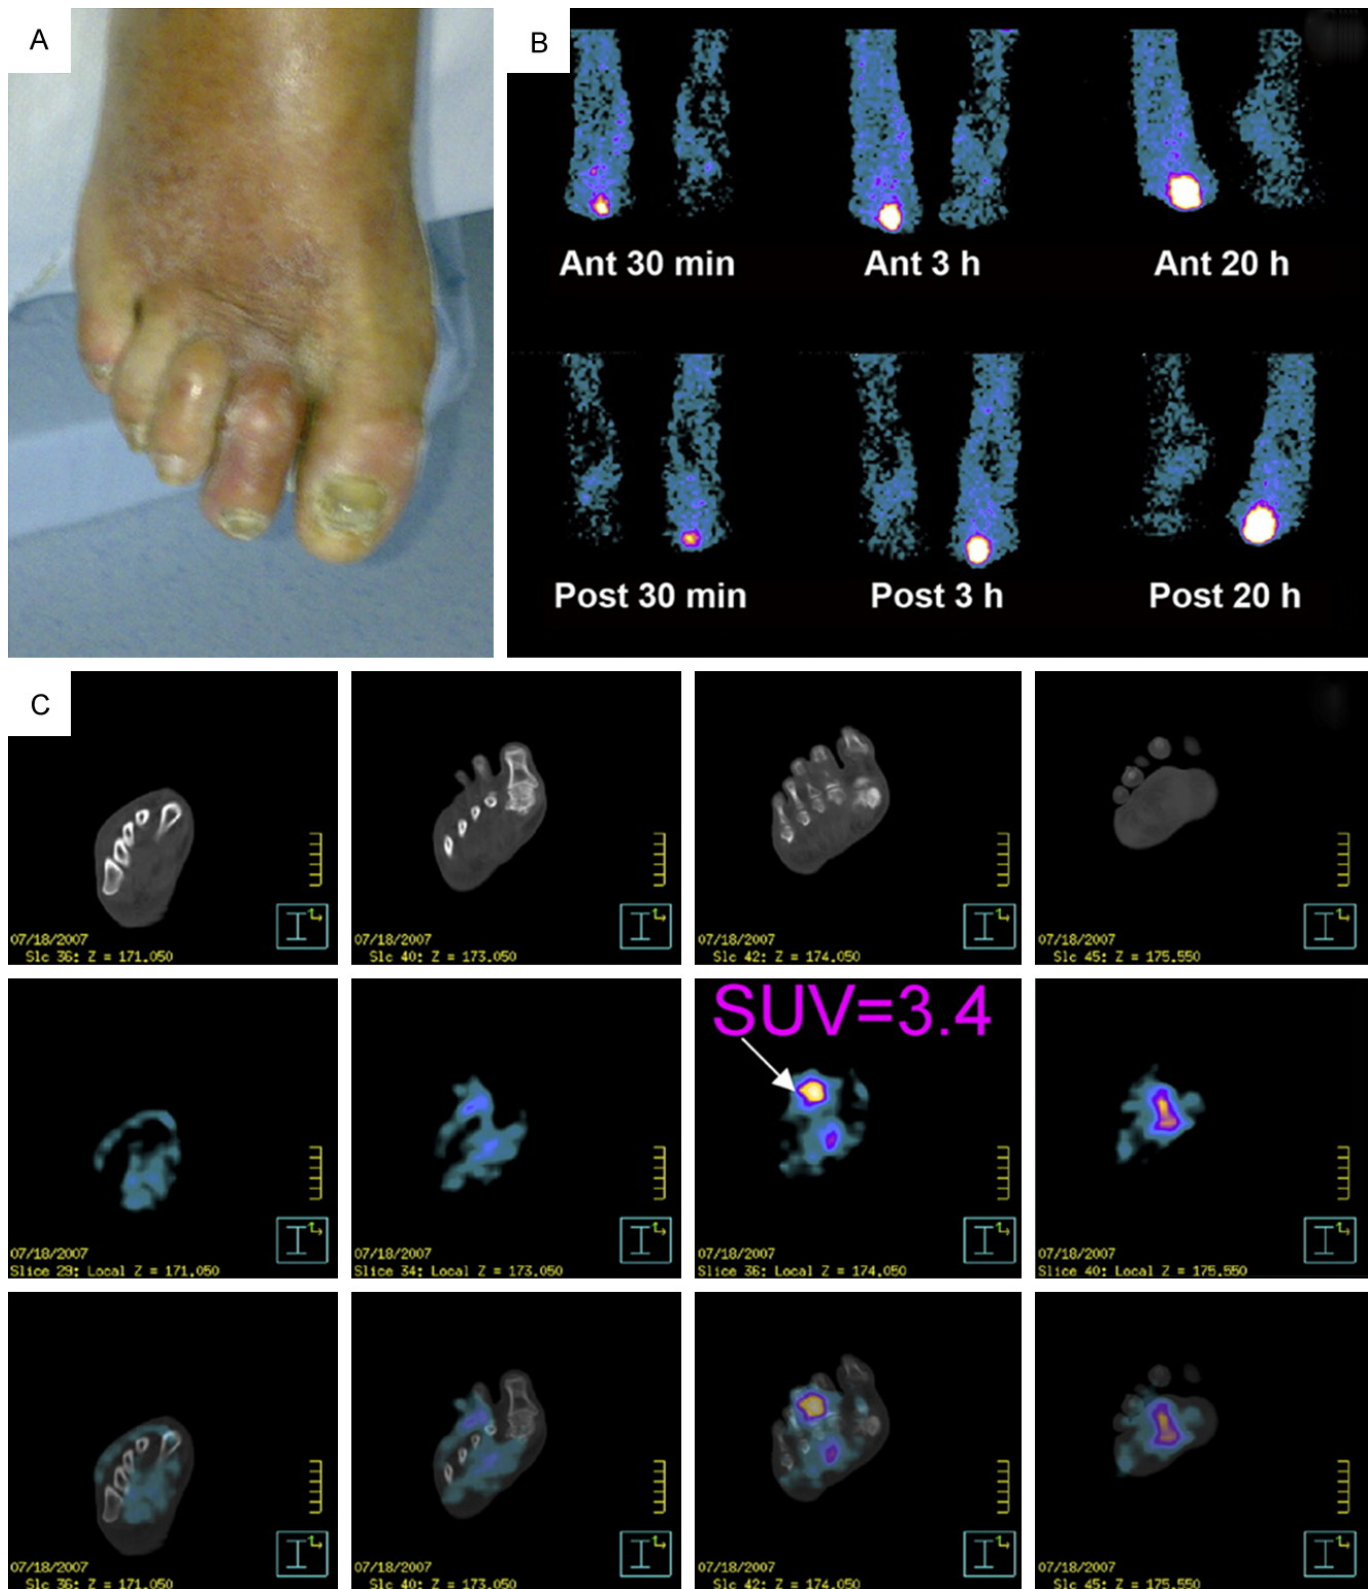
Concordant positive results for osteomyelitis in a diabetic foot patient. (A) Clinical image. (B) Anterior and posterior WBC scintigraphy at 30 min, 3 h, and 20 h showing T/B ratio > 2.0 increasing over time, consistent with osteomyelitis. (C) Transaxial ^{18}F -FDG-PET/CT at 1 h showing $\text{SUV}_{\text{max}} = 3.4$ with CT-confirmed bone localization. Reproduced from [28] © SNMMI.
